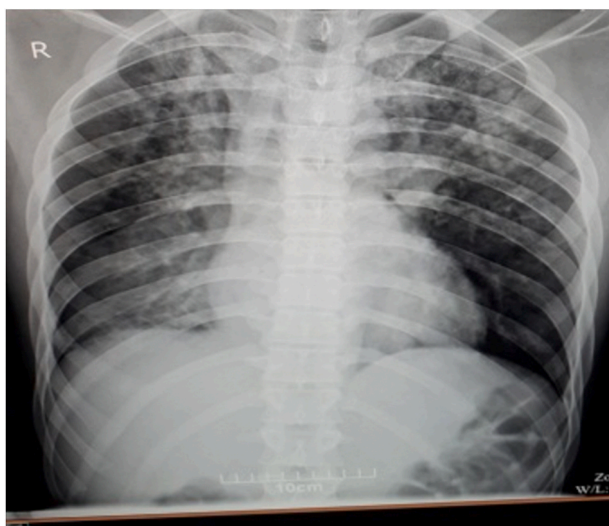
Chest x-ray of the patient showed ground glass opacities.
